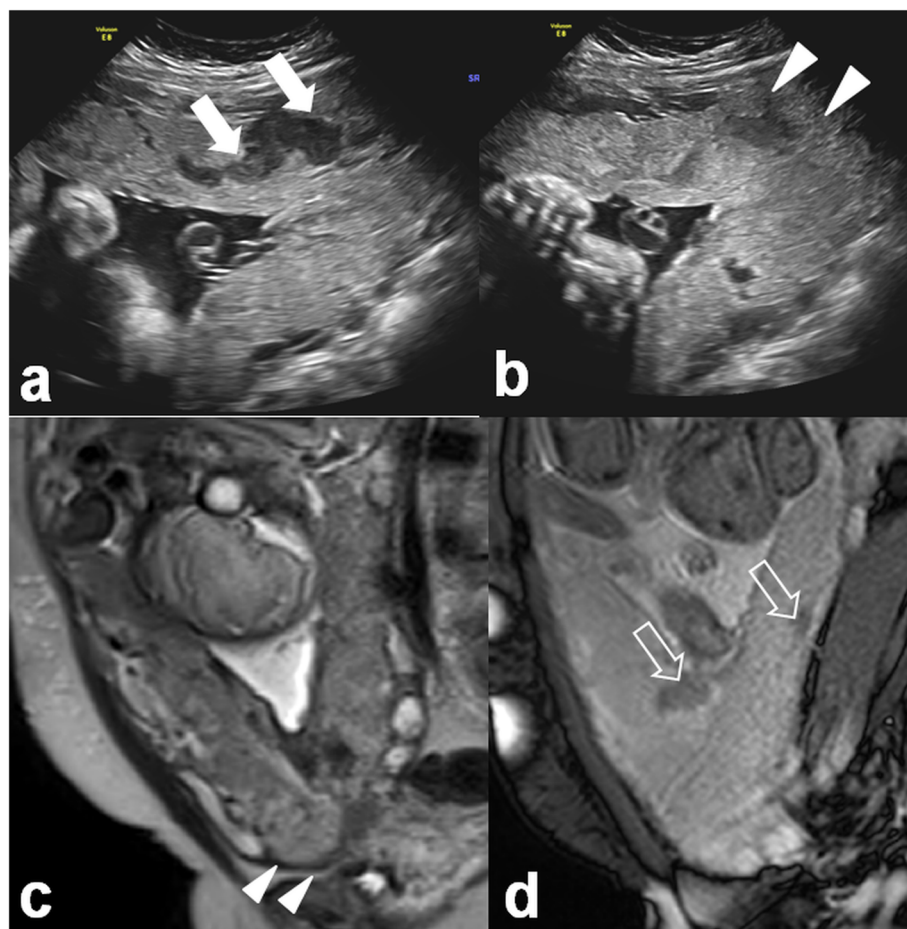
A 36-year-old woman (gravida –3) with history of previous Caesarean section. Sonography images (a, b) of the placenta show intraplacental venous lakes (arrows) and loss of uteroplacental interface (arrowheads). Sagittal T2 HASTE (a) and SSFP (b) images show placenta previa with loss of interface and focal bulge (arrowheads), heterogeneous placenta and dark bands (open arrows). Elective Caesarean section confirmed placenta accreta and obstetric hysterectomy was performed
